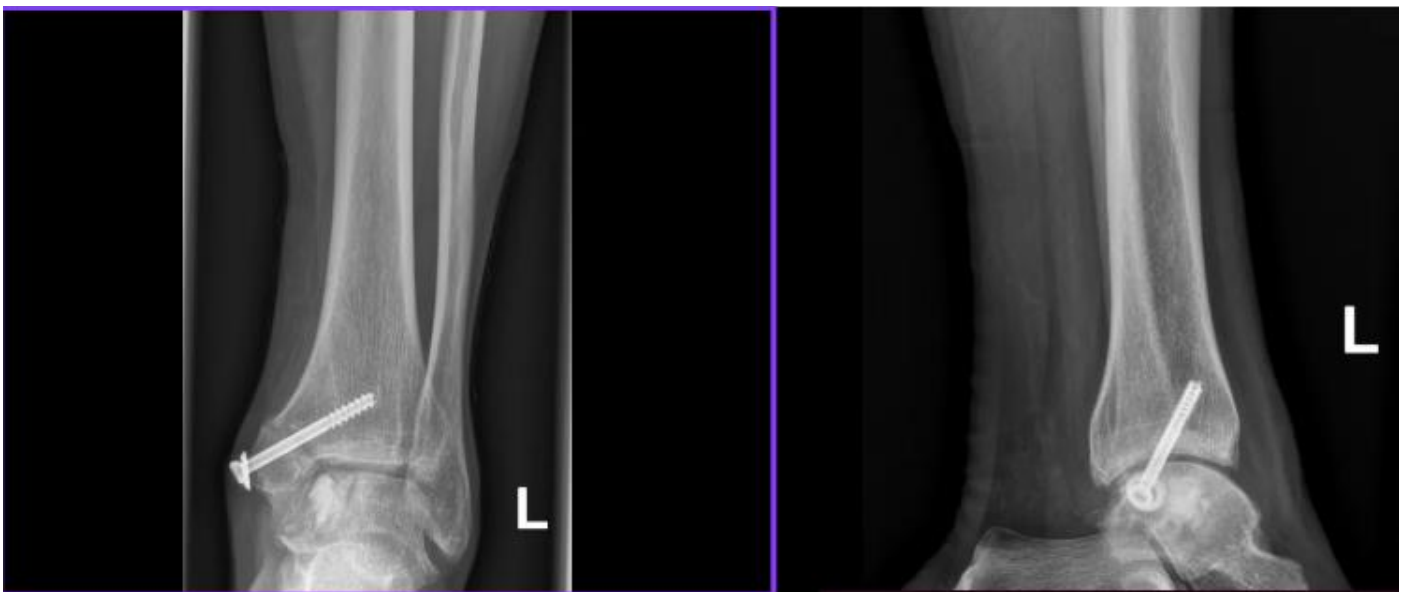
Postoperative x-rays of the left talus with osteosynthesis of osteotomized medial malleolus.
